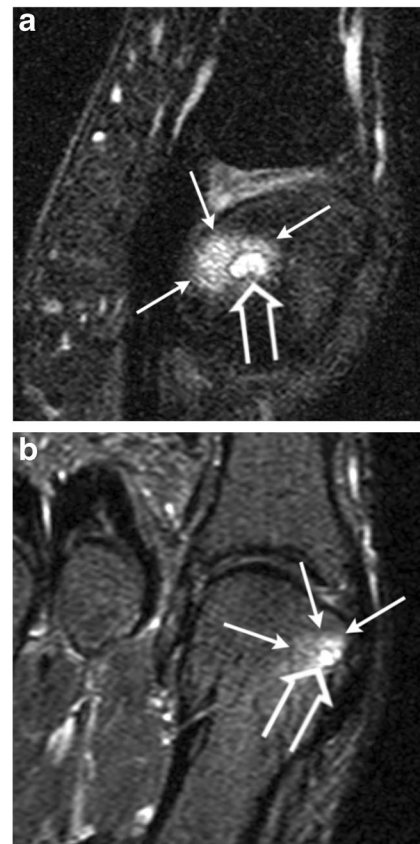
27-year-old male volunteer with bone marrow oedema-like signal changes (*arrows*) and subchondral cysts (*open arrows*) at the origin of the medial collateral ligament complex on fat-suppressed sagittal intermediate-weighted (A) and coronal STIR MR images (B)
